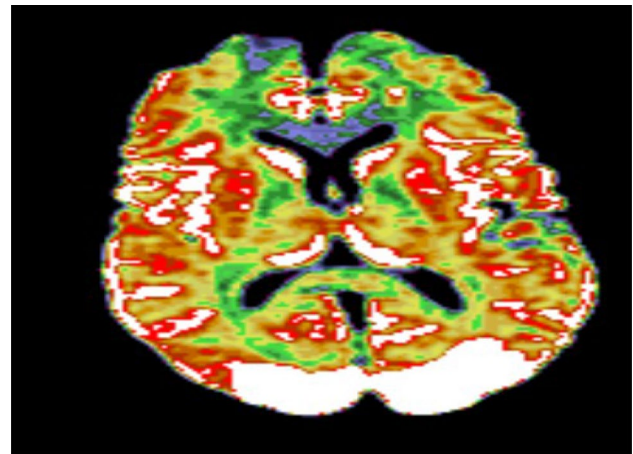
MRI of the brain, axial view wide areas of the parietal and occipital lobes edema involving both the lobes
